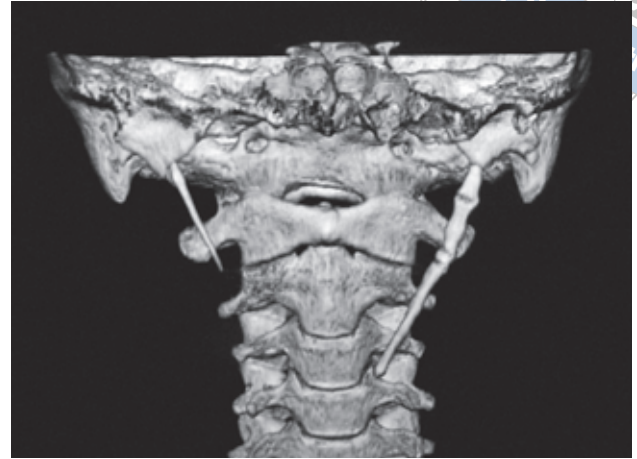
3D-CT showed the elongated left styloid processes extending to the middle neck, which might have compressed the carotid artery and vagus nerve.
